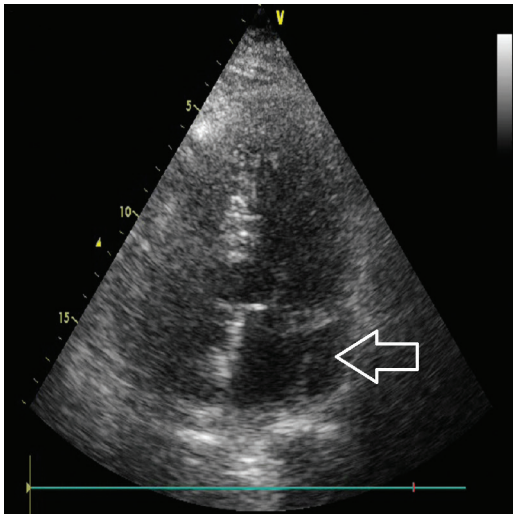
Transthoracic examination, four-chamber view. Persistent left superior vena cava (PLSVC) visible as an untypical accessory structure in the left atrium area.
